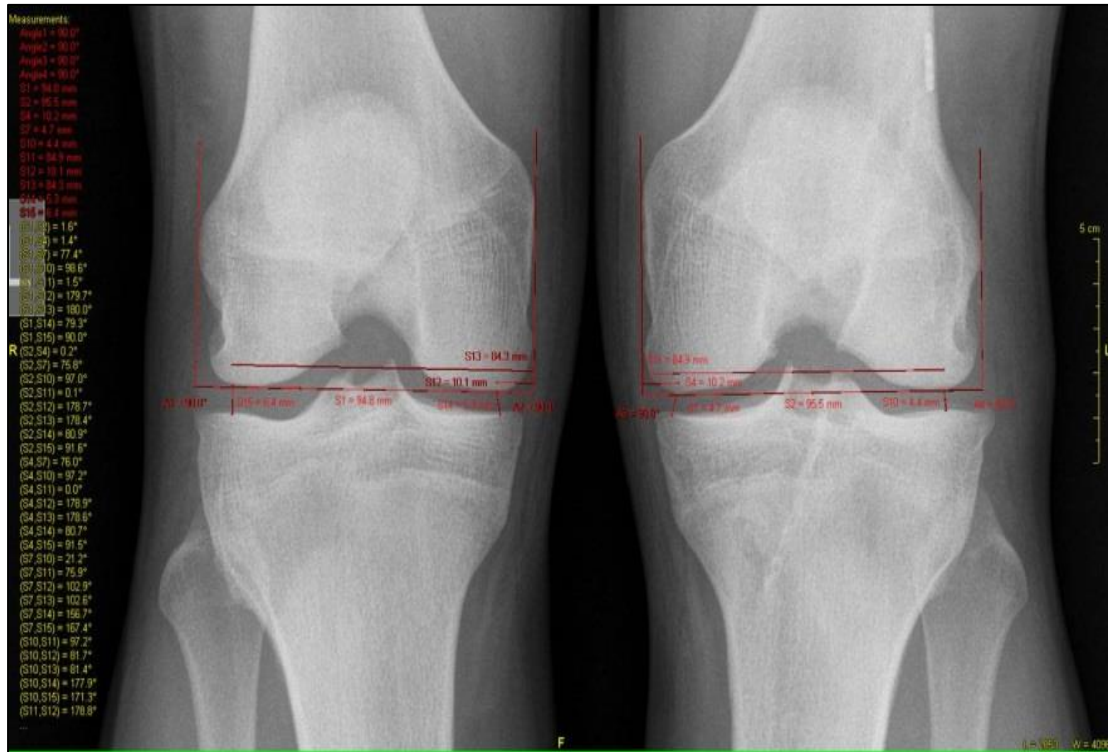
Example of minimum joint space width measurements on a posterior-anterior 30° bent knee radiograph in a patient 5 years after ACL injury.
